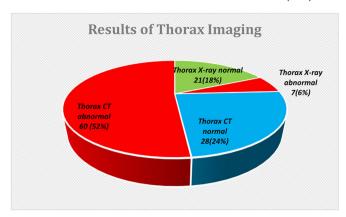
The thorax imaging of 116 patients with COVID-19. CT = computed tomography. Eighty-eight patients submitted to thorax CT and 28 to thorax X-ray. In parenthesis, the percentual among the total number of patients.
